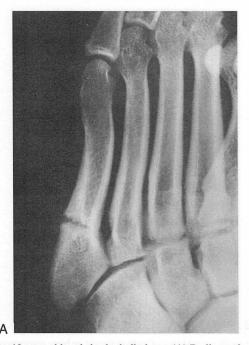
19-year-old male basketball player. (A) Radiograph at the time of initial presentation reveals osteosclerosis in the cortex, radiolucency around the fracture line and occlusion of the bone marrow cavity. The diagnosis was type III Jones fracture. (B) Radiograph at 10 weeks after operation shows bone union.
